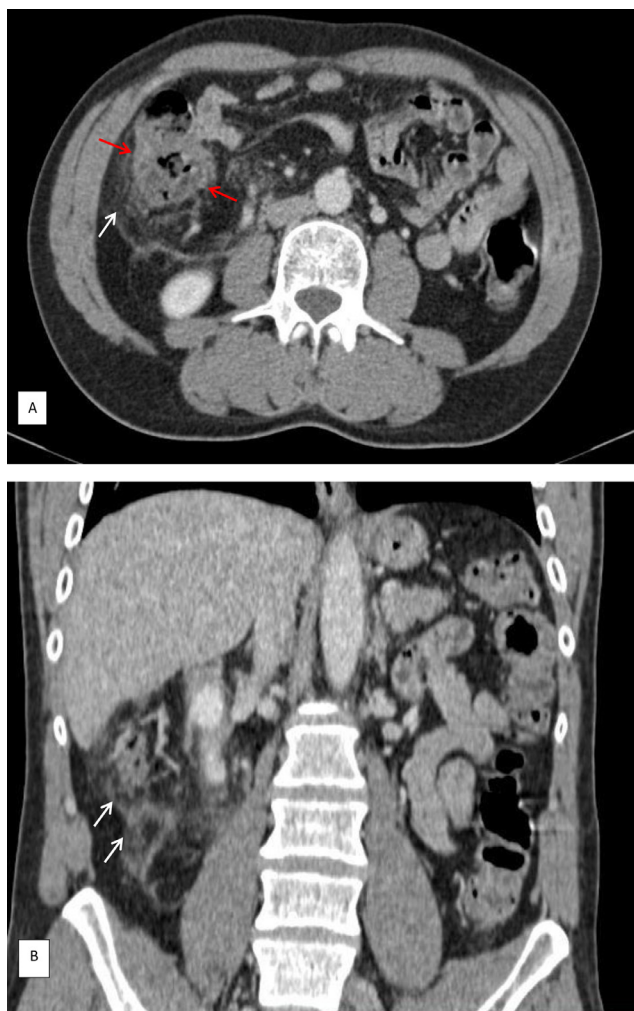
Contrast-enhanced abdominal computed tomography image (A: axial, B: sagittal), demonstrated diffusely increased fat density throughout the anterior omentum between the right peritoneum and the ascending colon (white arrow), which is the site of a parietal thickening (red arrow).
